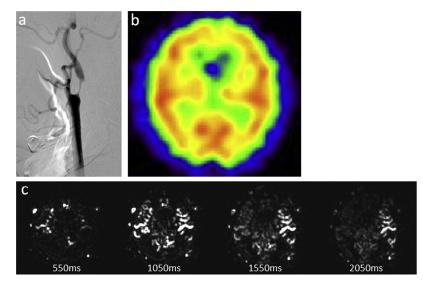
Preoperative imaging. (A) Left common carotid angiogram revealed a high-grade stenosis of the left internal carotid artery (ICA) immediately distal to the common carotid artery bifurcation. (B) The brain single-photon emission computed tomography (SPECT) at rest demonstrated no significant laterality of cerebral blood flow (CBF). (C) Multiphase arterial spin labeling (ASL) images with postlabeling delays (PLDs) of 550, 1050, 1550, and 2050 ms demonstrated the relatively delayed perfusion in the left hemisphere.
